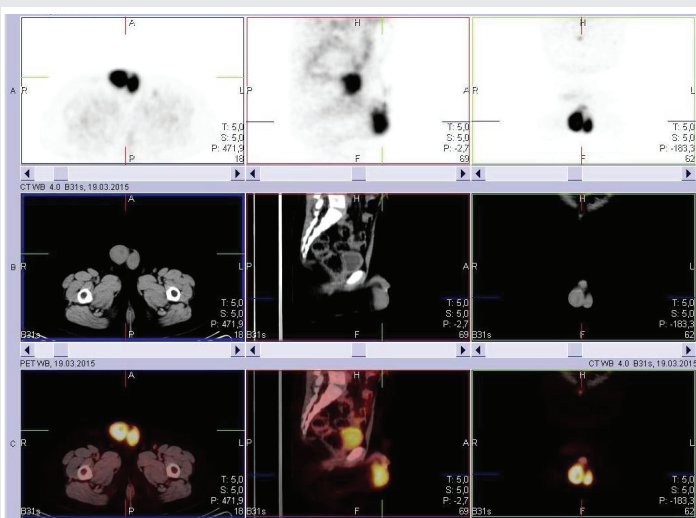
18-fluorodeoxyglucose positron emission tomographies (FDG-PET) scan showing intense FDG accumulation in both testes.
